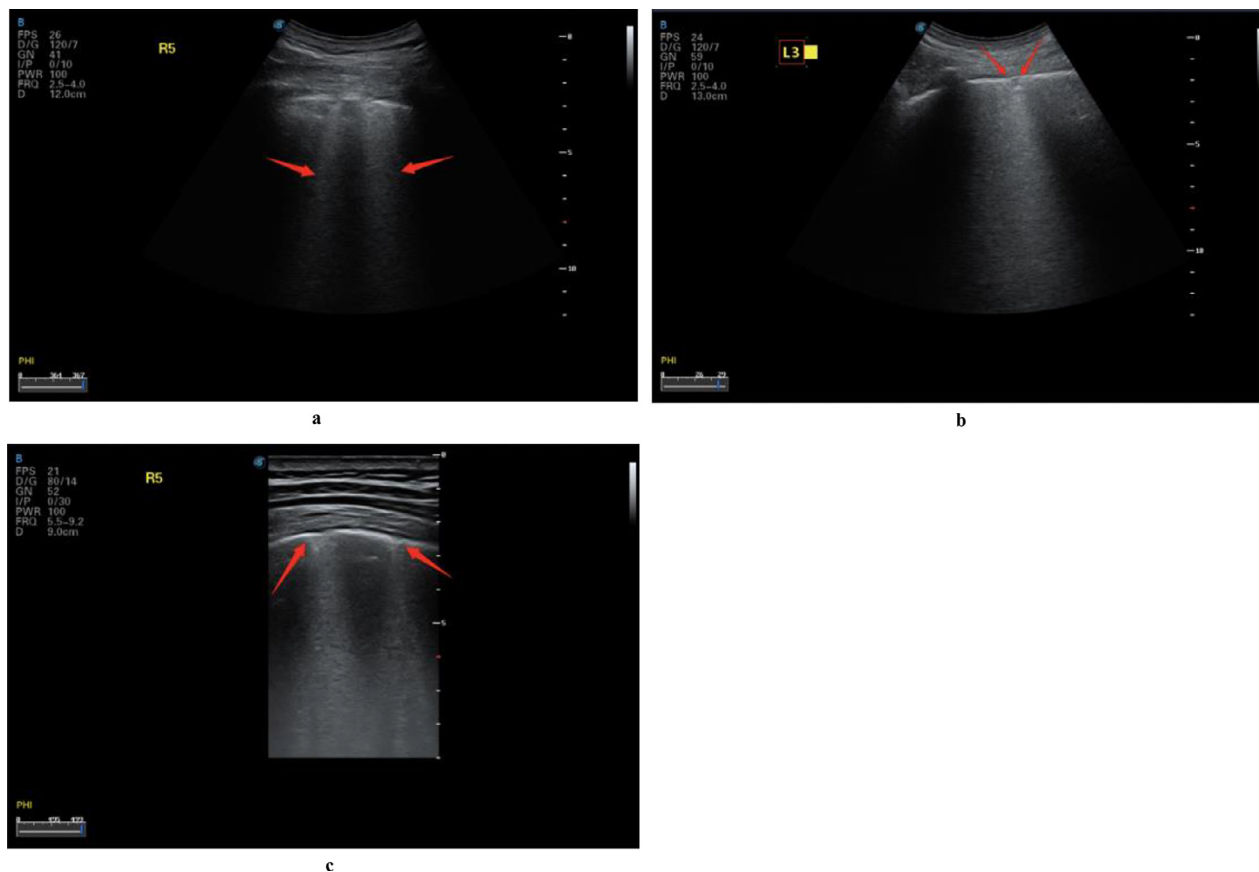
Lung ultrasound images of multiple COVID-19 cases demonstrating different patterns of B-lines. (a) B-lines and waterfall sign in the right posterior upper area (red arrow), with an unsmooth pleural line. (b) The pleural line in the right posterior lower area is unsmooth and thin, with diffused B-lines and white-lung sign; A-lines have disappeared. (c) B-lines in the left posterior lower area, with A-lines having disappeared; small patchy lesions are observed, and the pleural line is discontinuous (red arrow). Reprinted with permission from Huang et al. (2020).
